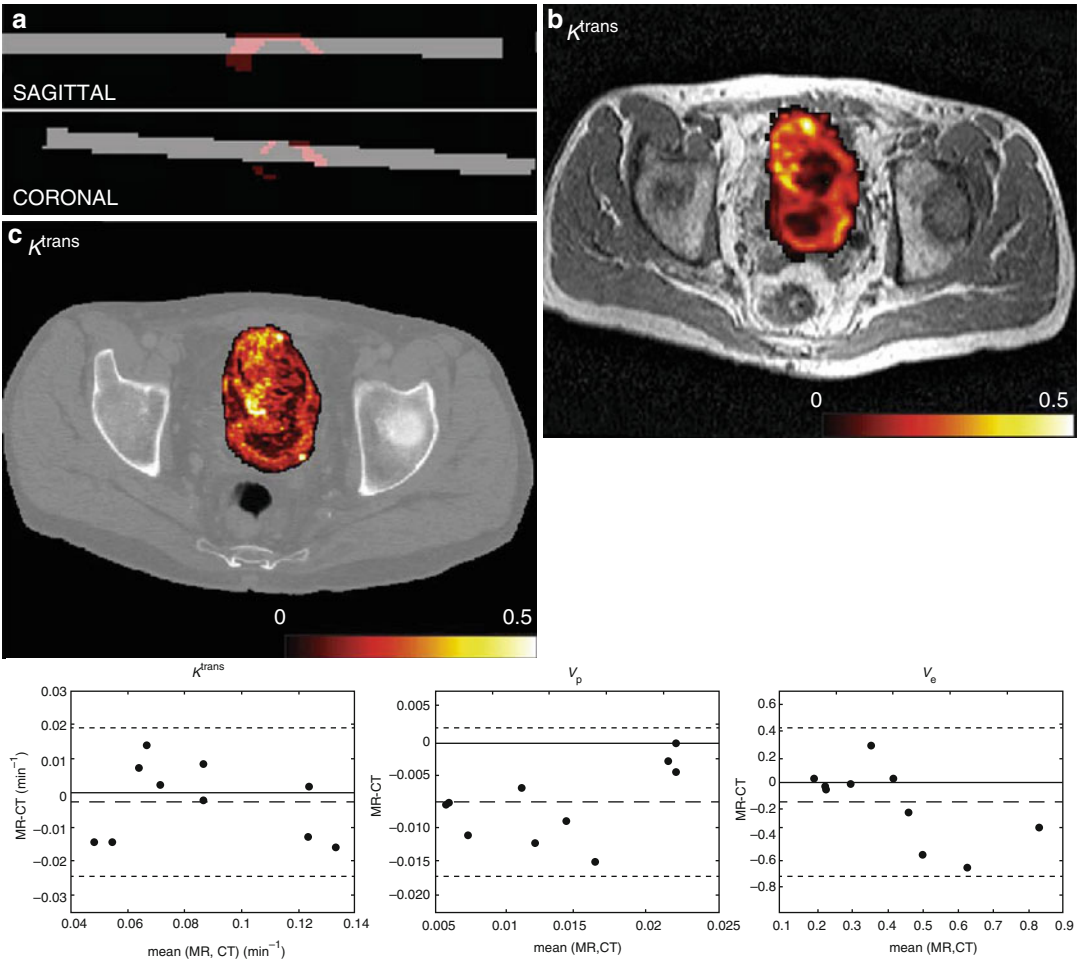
(a) CT volume (*grey*) backtransformed into MR space and intersecting tumour ROI (*red*), sagittal and coronal views in a patient with bladder cancer. (b) Example of K^{trans} map for DCE-MRI overlaid onto T_2 -weighted anatomical image after affine transformation to CT space. (c) Example of K^{trans} map for DCE-CT at native resolution
